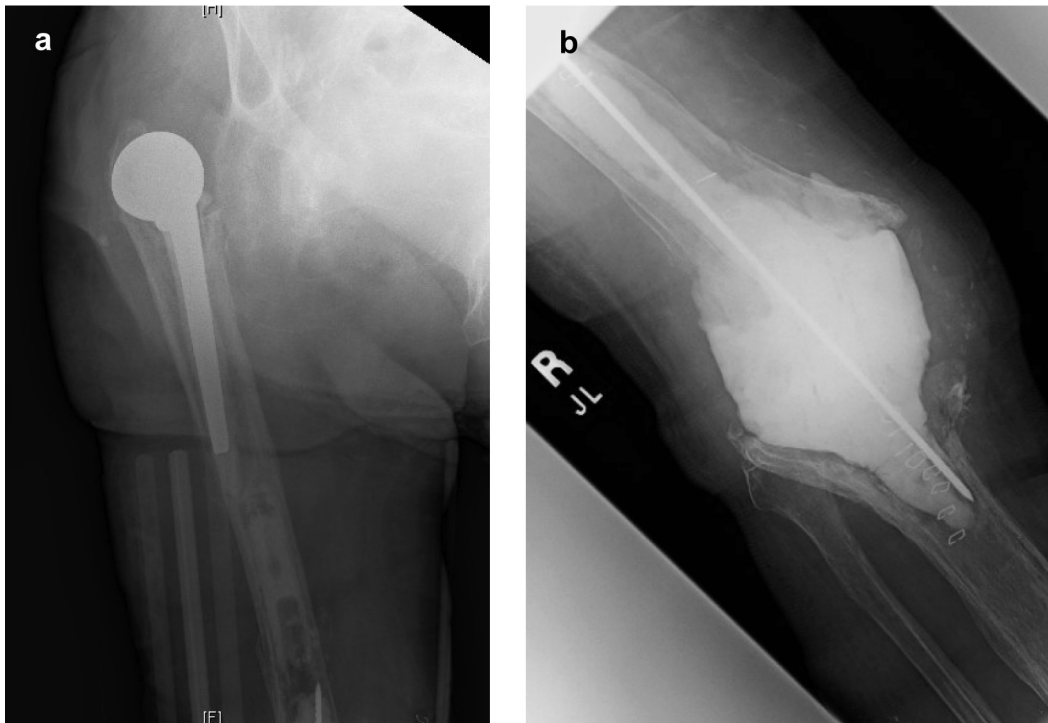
(a) AP radiograph of case/patient 1, showing dislocated cemented hemiarthroplasty with severe associated femoral bone loss; (b) AP view of the same patient's ipsilateral knee with a static cement spacer in place. AP, anteroposterior.
